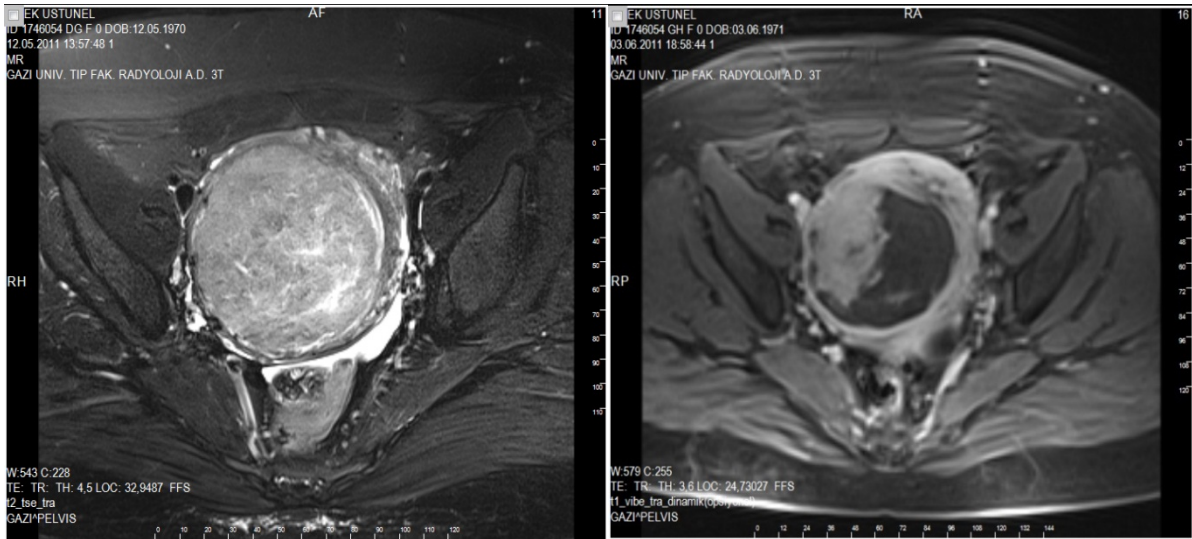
Patient DU: MR image of the pre and post-embolization leiomyoma
